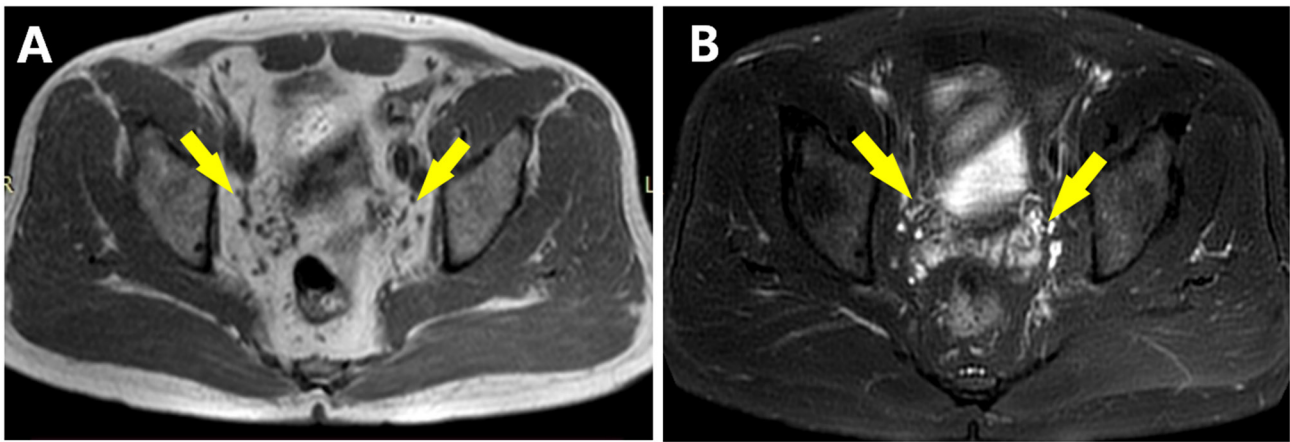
Follow-up. (A) T1WI and (B) T2WI magnetic resonance imaging after 6 months of treatment, indicating that the masses had completely disappeared. T1WI, T1-weighted imaging. Yellow arrows indicate the previous location of the soft tissue masses.
